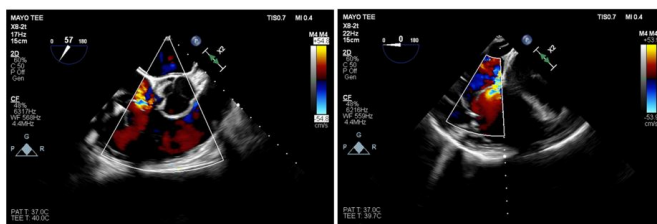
Intraoperative transesophageal echocardiogram showed severe tricuspid regurgitation via perforated anterior leaflet.
